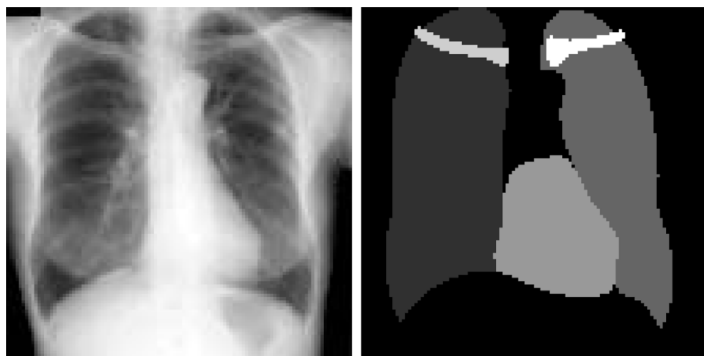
Images from Computed Tomography analyzed by CCCP, [2].
